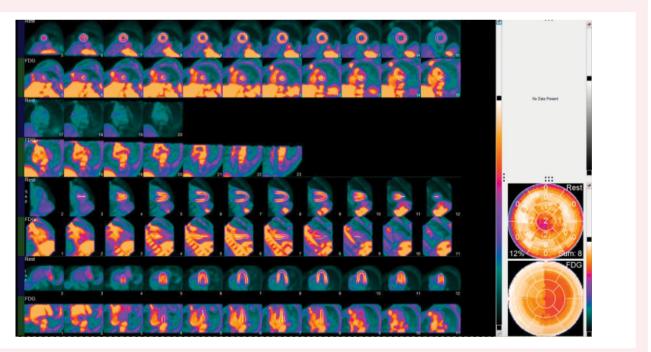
Follow-up FGD-cPET. A follow-up scan performed several months following the initiation of immunosuppressive treatment demonstrated that the initial FGD-avid foci in the right atria were no longer visible. FDG-cPET, ¹⁸F-fluorodeoxyglucose-positron cardiac positron emission tomography.
